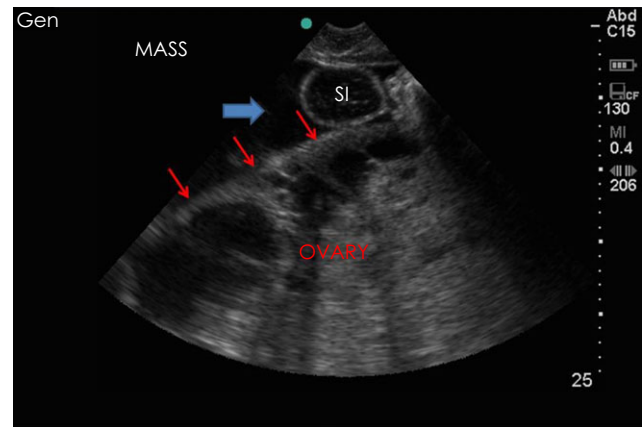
Case 2: Ultrasound image obtained per rectum of the ovarian mass with hypoechoic cystic structures and more homogeneous soft tissue stroma within it. Red arrows delineate the dorsal border of the mass, the excessive volume of hypoechoic peritoneal fluid (blue arrow) is also visible. SI = small intestinal loop.
